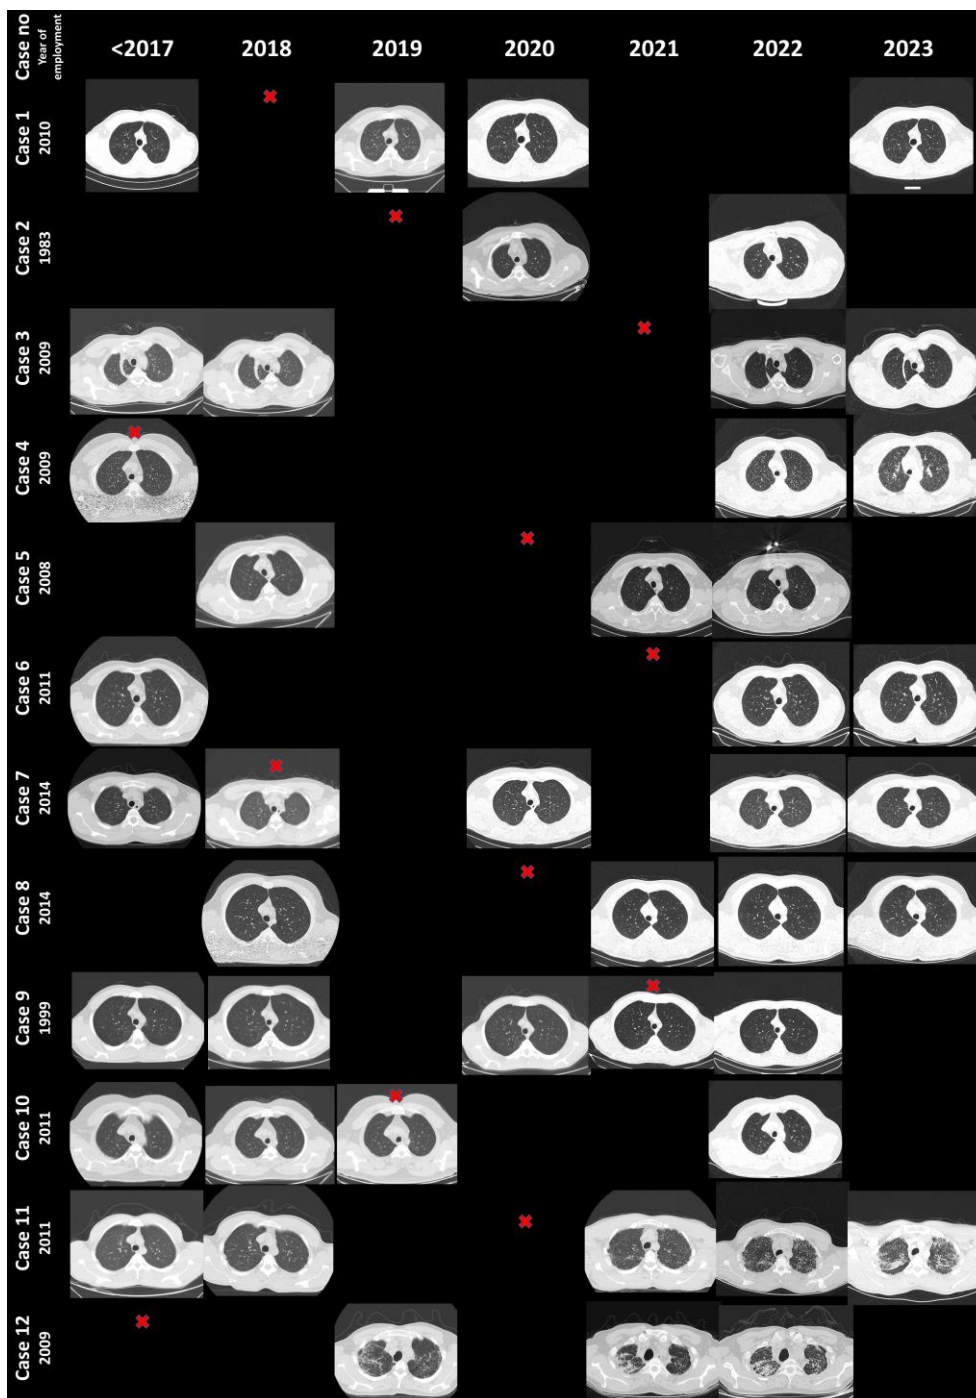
HRCT images of pneumoconiosis cases in the follow-up x = Years of the diagnosis. Note: Due to the problem in the archive system, some external center radiology examinations could not be reached
